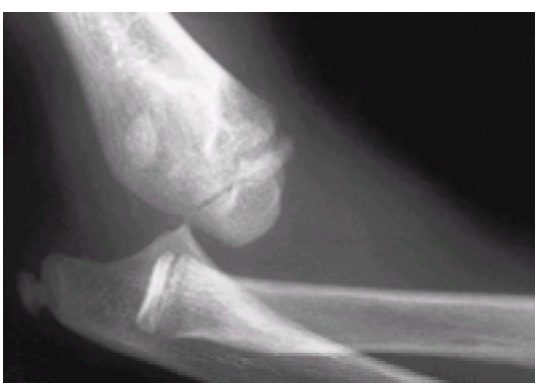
Elbow dislocation in an 8-year-old girl. A displaced fracture of the medial epicondyle was evident on the postreduction radiographs.
